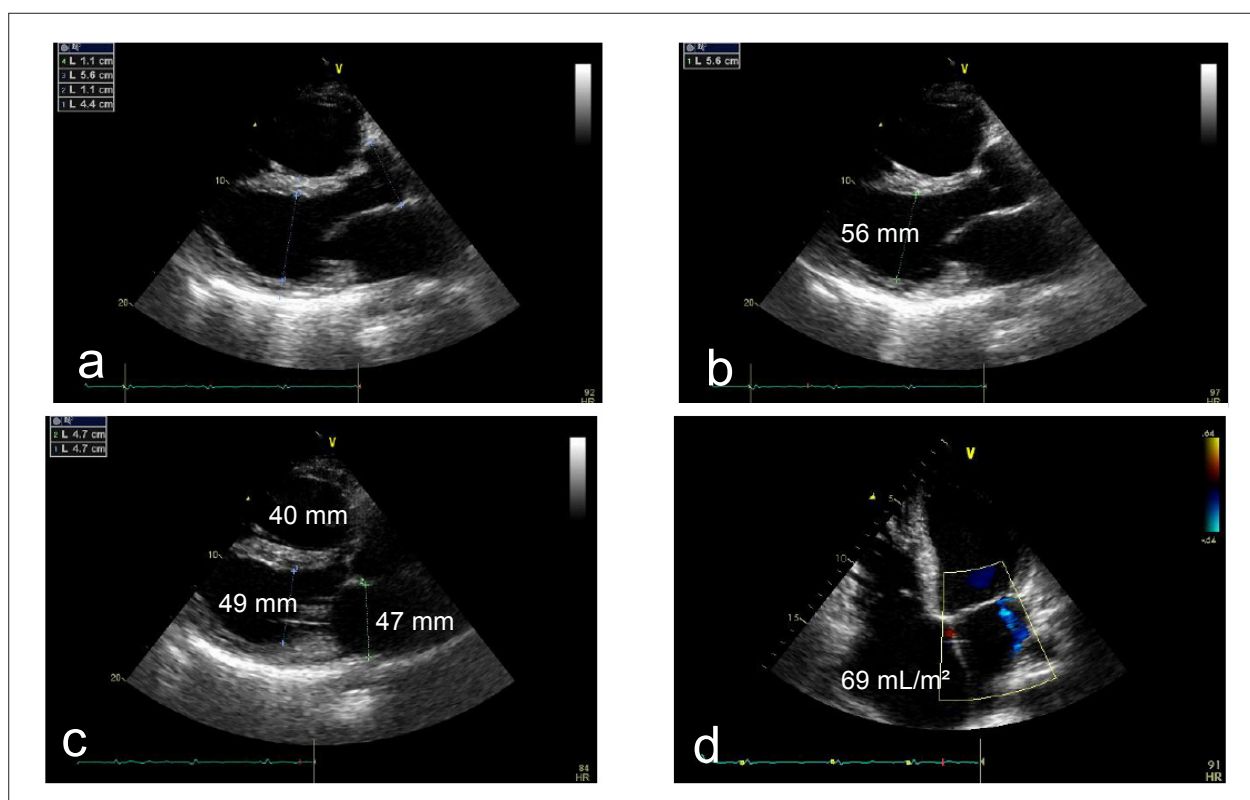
Transthoracic echocardiogram, longitudinal parasternal view (a, b, c) and four-chamber view (d) of the left ventricle. Note the enlarged atria and right ventricle.
